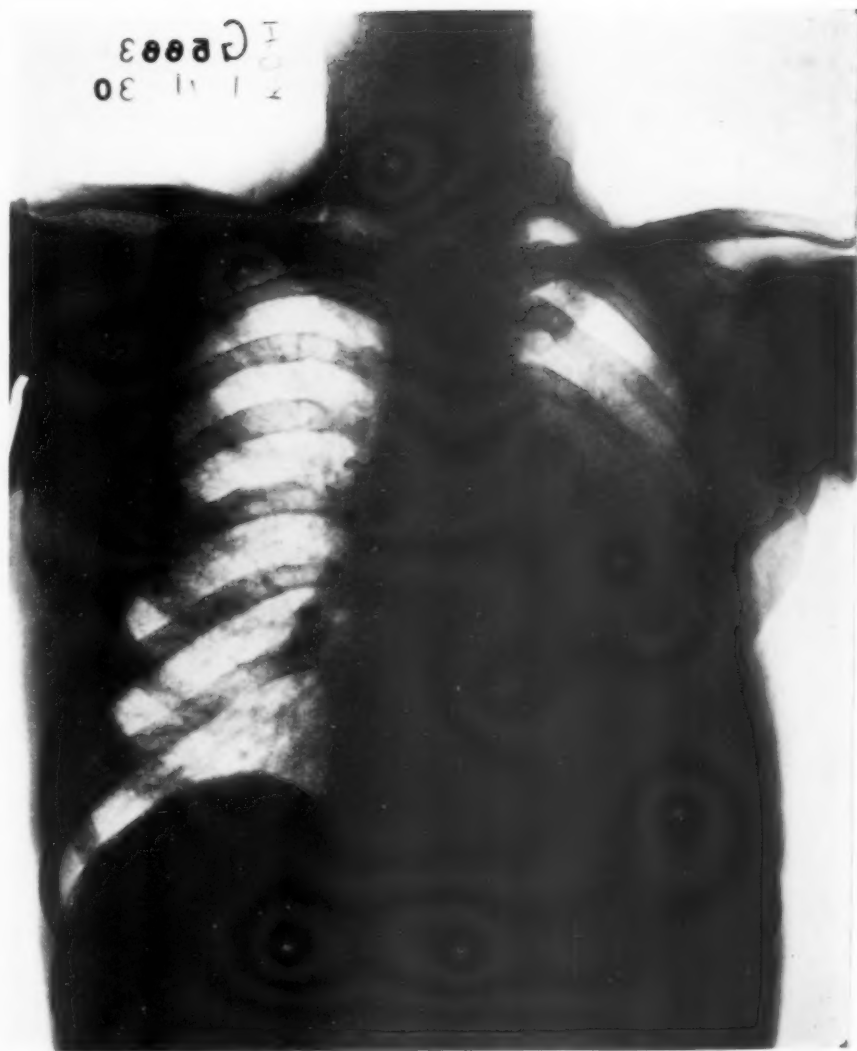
(Nov. 13, 1930.) Absent aeration of the left lower lobe. Small effusion in the costo-phrenic space. Left chest smaller than the right. Moderate compensatory emphysema of the right lung. The left border of the heart shadow obscured by lung pathology. (Interpretation of the x-ray films was by Dr. Richard A. Rendich, roentgenologist at Kings County Hospital.)
